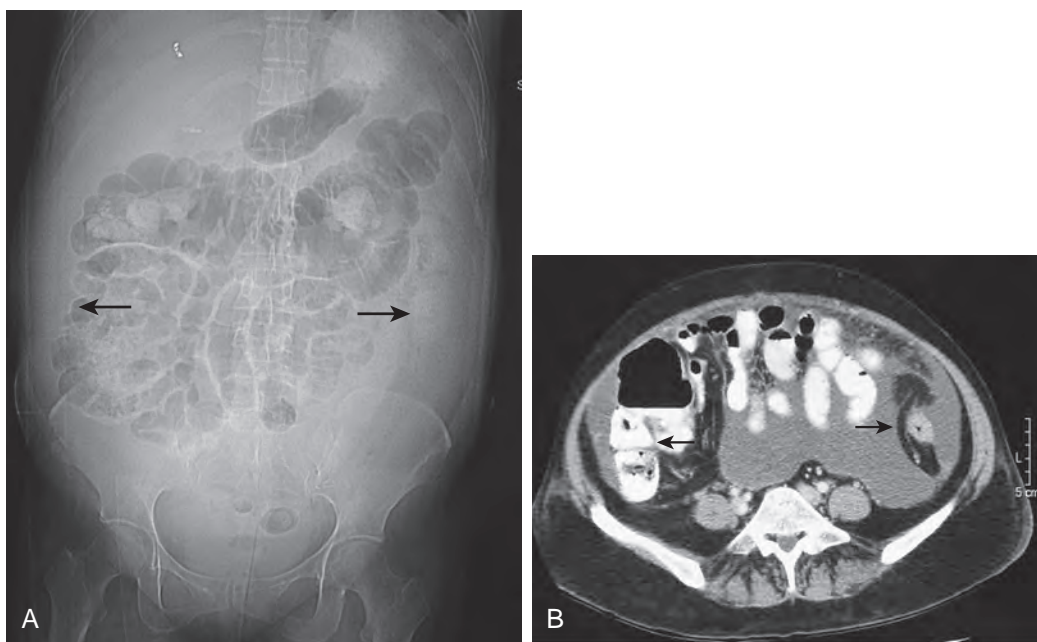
Intraperitoneal fluid (hemorrhage) in paracolic gutters. A. Supine abdominal radiograph in a patient with a traumatic liver laceration shows a large amount of fluid in both paracolic gutters (arrows) displacing bowel medially from the flank stripes. Also note loss of the hepatic angle normally outlined by extraperitoneal fat. The bleeding was controlled by embolization of the liver (note the radiopaque coil overlying the liver). B. Axial CT scan of the abdomen confirms the presence of ascitic fluid displacing adjacent bowel (arrows) from the paracolic gutters.
